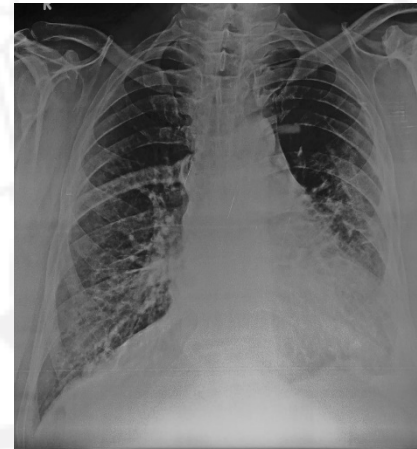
x-ray showing response after therapy
